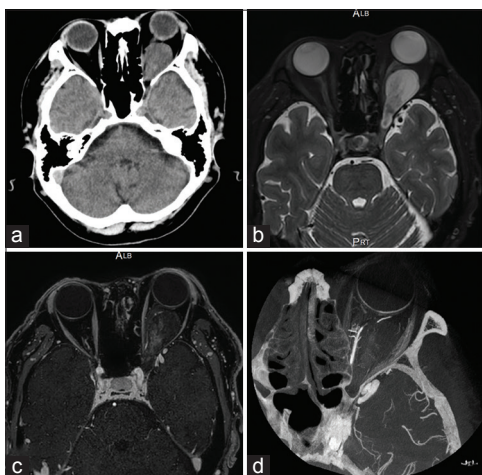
Computed tomography showed the left intraconal orbital tumor compressing the globe with resultant exophthalmos (a). T2-weighted magnetic resonance imaging (MRI) showed a hyperintense tumor (b). Gadolinium-enhanced fat suppression T1-weighted MRI showed a heterogeneous enhancement (c). VasoCT showed some feeders from the ophthalmic artery (d).
